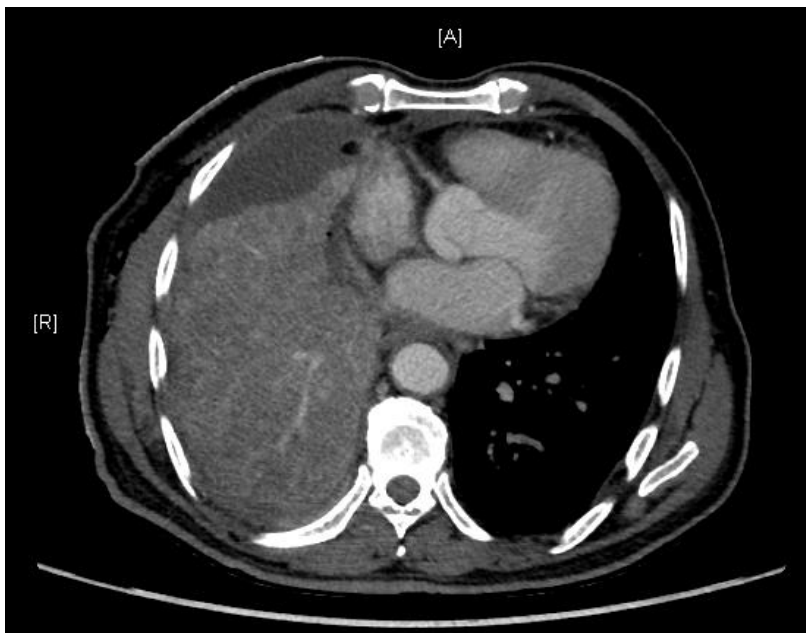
"CT angiogram sign"
